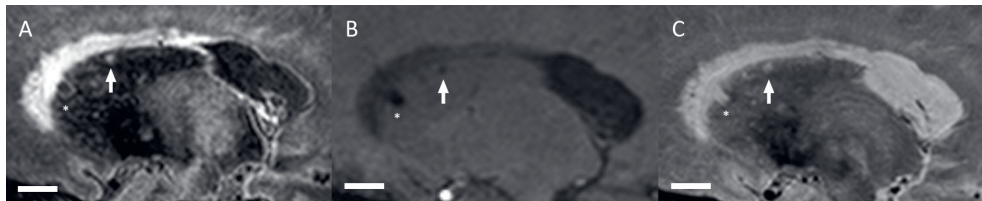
A non-cavitated small infarct (arrow) in the body of the right caudate nucleus in a 69-year old male shown on sagittal FLAIR (A), T1-weighted (B) and T2-weighted images (C) of the 7T MRI scan. This lesion is hyperintense on the FLAIR image, hypointense on the T1-weighted image and hyperintense on the T2-weighted image. Note the presence of a cavitated small infarct (*) in the head of the caudate nucleus. Scale bar indicates 10 mm.
